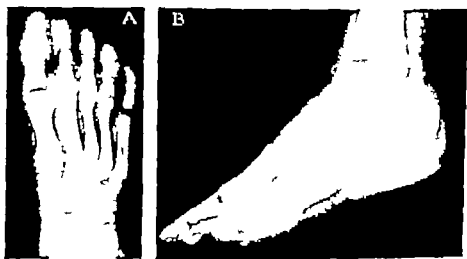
Köhler's disease of the navicular bone. Roentgenograms showing characteristic changes of the navicular bone. A Anteroposterior view note the irregular distribution of calcium. B Lateral view note the decrease in width and increase in density. (From Hauser: *Am. J. Dis. Child.*)
